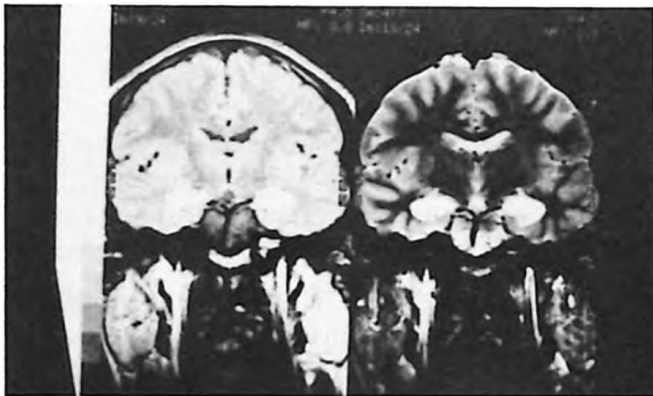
T2 weighted images of the initial MRI demonstrated high signal intensity of the bilateral hippocampal region with no apparent structural change.
